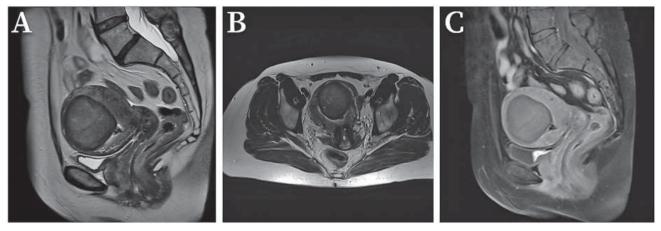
Postprocedural MRI of the same patient. Sagittal and axial T2-weighted MR image (A, B) showing a volume reduction of the fibroid after the procedure, which measures now 69 cm<sup>3</sup>, accounting for 73,36% volume reduction. Sagittal post-contrast T1-weighted MR image with fat saturation (C) showing characteristic loss of contrast opacification showing complete fibroid necrosis and marking the procedure successful.
